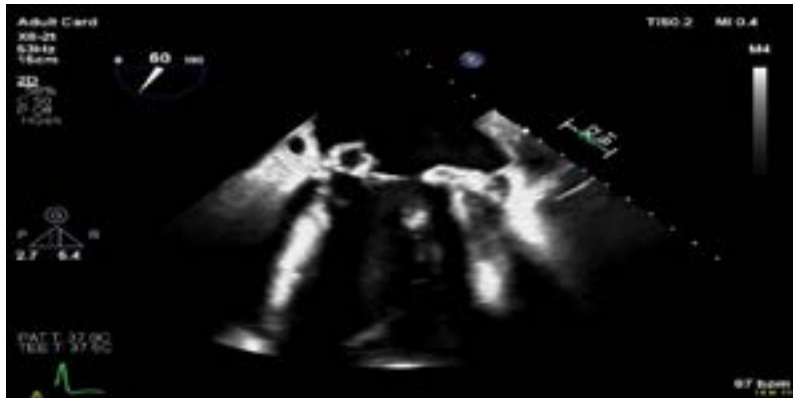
Transesophageal Echocardiogram A: Mid- -Oesophageal 2 chamber view showing formation of Posterior Mitral Valve leaflet aneurysm. B: Colour Doppler assessment of MV showing MR due to perforation of mitral valve aneurysm.
